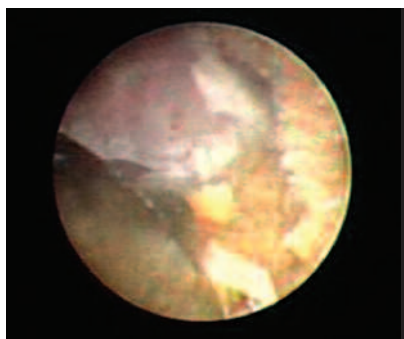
Cleaning up small fragments, note the concentric arrangement of the dual ultrasonic probes
